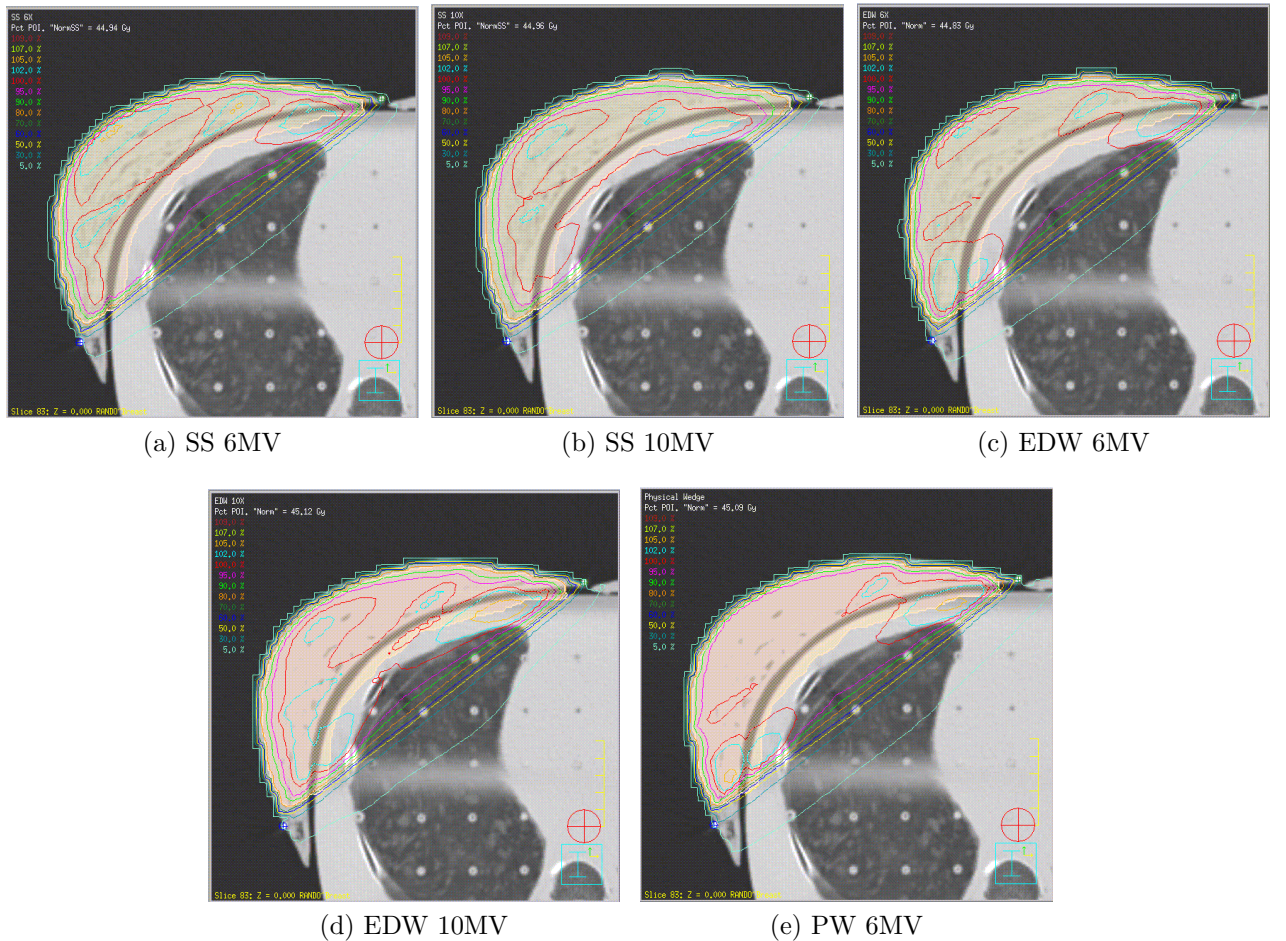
Isodose distribution on the zero slice (CT reference) for the five breast plans. The pink and red isodose lines represent the 95 and 100% dose coverage, respectively.
